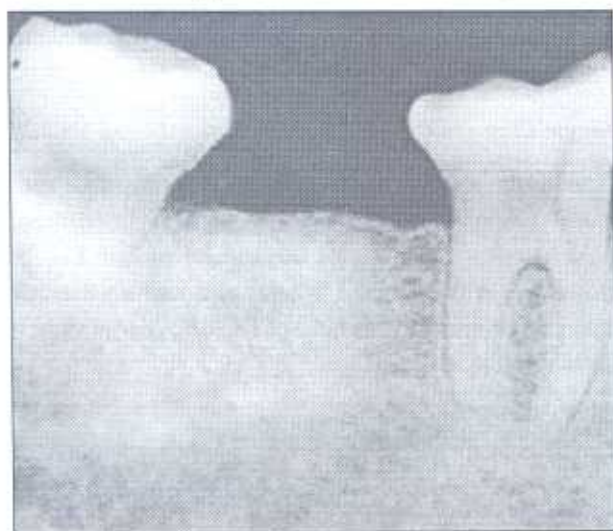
The mandibular second molar in the original radiograph (Fig. 1) has been extracted by application of the software program.
